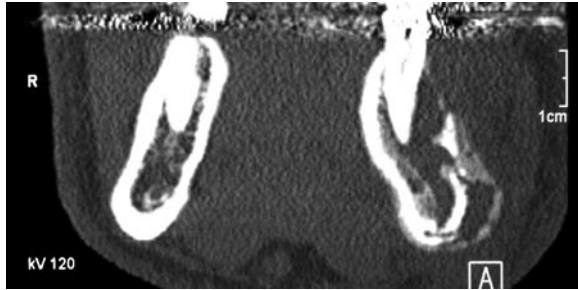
Coronal view corresponding to axial CT scan shown in Fig. 2.11. (This case is described in detail in Chap. 12, case report 6)
